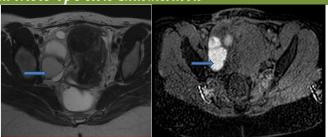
a and b: MRI axial sequence T2 and T1 FAT sat: right ovarian cystic mass with T2 hypersignal and T1fat sat compatible with an endometriotic cyst.
